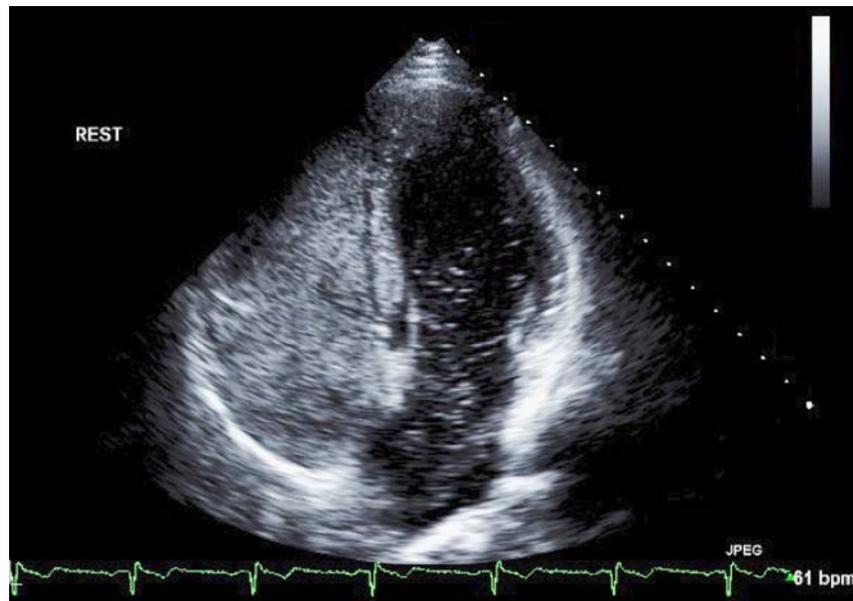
Agitated saline contrast echocardiography in this 28-yr-old female who complained of migraine headaches shows good opacification of right heart chambers. Clear evidence of right-to-left shunting (appearance of saline bubbles into left heart chambers) occurred early during rest. She was diagnosed with a secundum atrial septal defect. (Please *see* companion DVD for corresponding video.)
